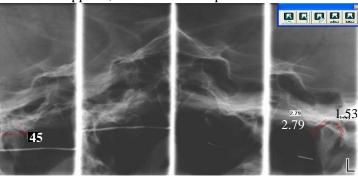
Radiographic image, linear and angular measurement. A and D TMJ in closed position, B and C TMJ in opened position. A: angular measurement, D: Linear measurement
